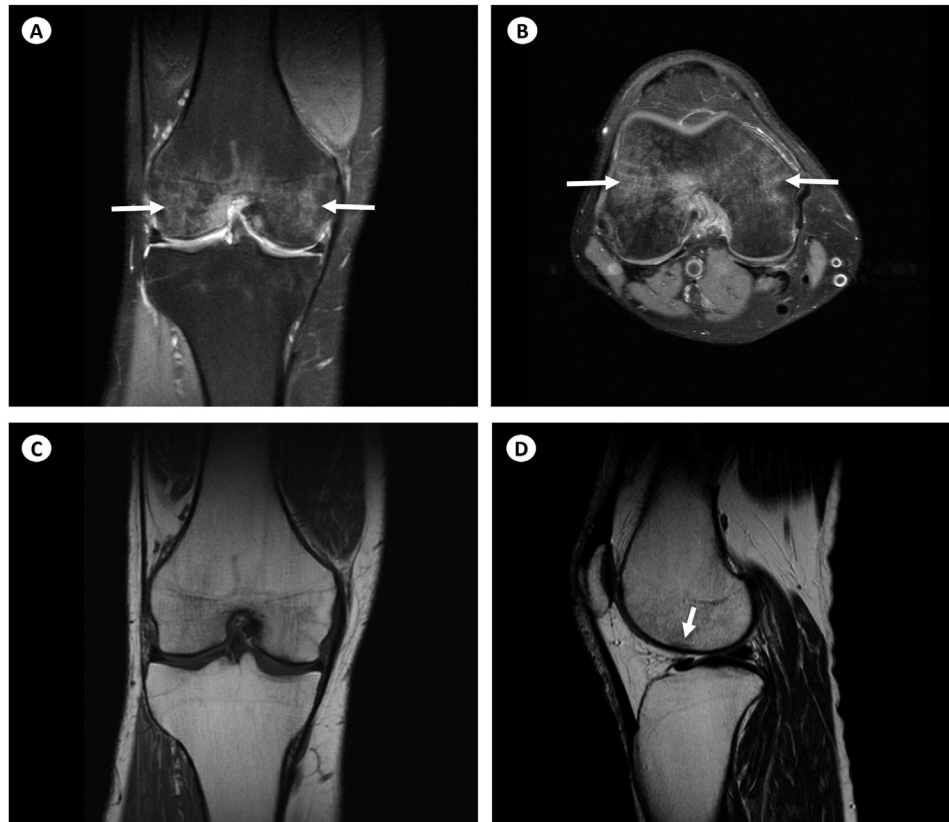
(A) Coronal and (B) axial proton density (PD) fat-saturated magnetic resonance (MR) images of the right knee demonstrate diffuse heterogeneous signal hyperintensity affecting the bone marrow of both femoral condyles (arrows), indicating bone marrow edema. (C) Coronal T1-weighted MR image of the right knee only displays mild areas with partial loss of the normal fatty marrow signal in the corresponding regions. (D) Sagittal T2-weighted, non-fat-saturated image at the level of the medial part of the lateral femoral condyle barely visualizes a thin subchondral fracture line of low signal intensity (arrow).
